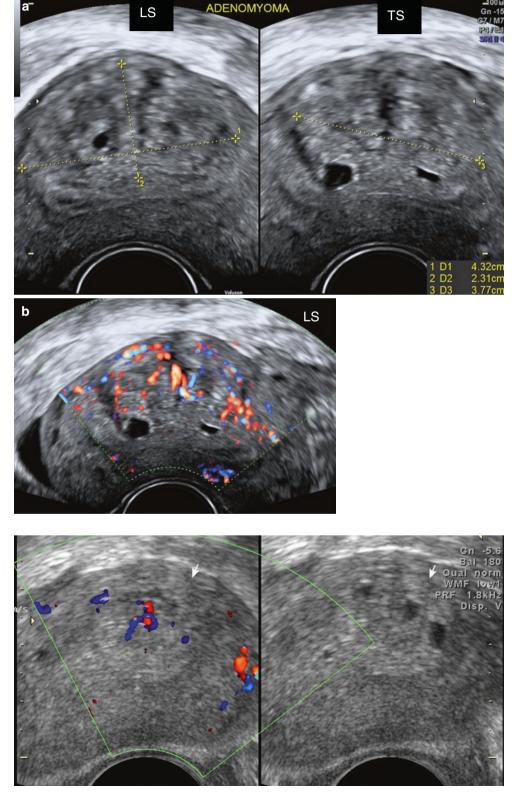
Poorly circumscribed area showing coarse echoes, cystic spaces and central vascularity, suggestive of an adenomyoma seen on (a) Doppler and (b) greyscale
